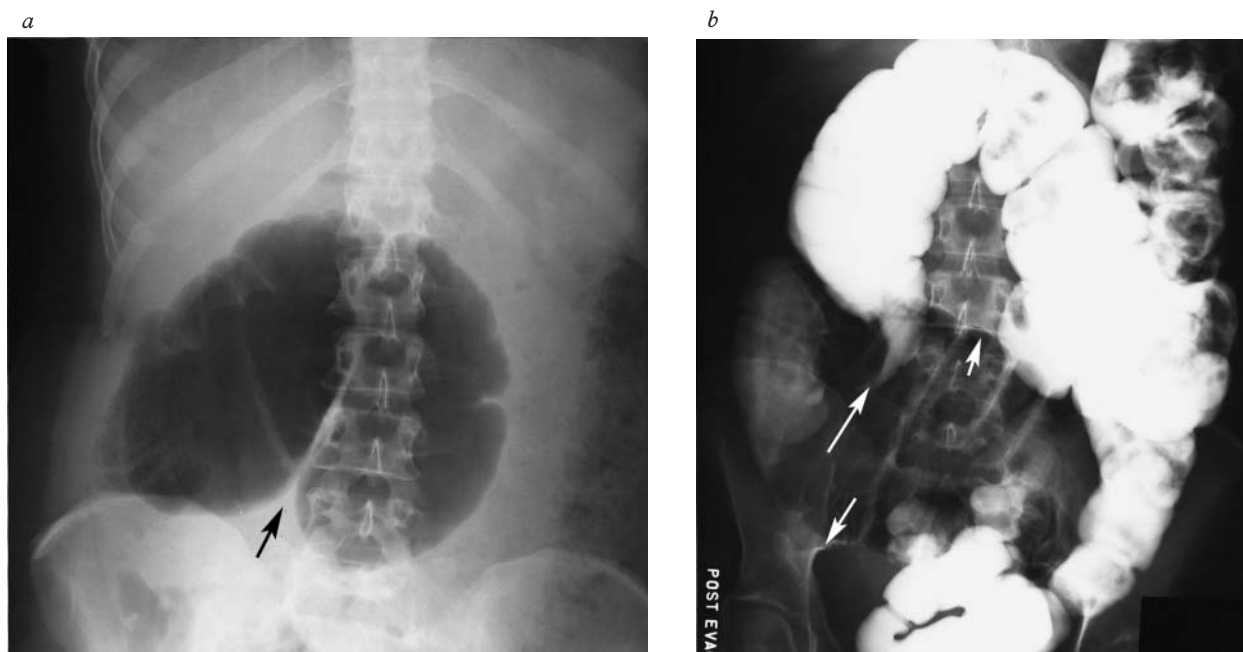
(a) Radiograph from a patient with cecal volvulus shows a dilated cecum with no air distally in the colorectum. Convergence of the medial walls of the loop (*black arrow*) points to the right, a typical finding in cecal volvulus. (b) Barium examination demonstrates a bird's beak deformity tapering at the point of volvulus (*large white arrow*). Note walls of dilated cecum (*small white arrows*).
